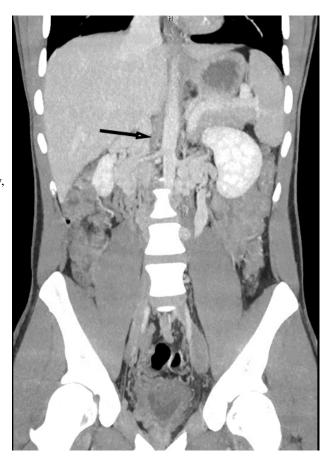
CT venogram coronal view with the black arrow demonstrating the absence of IVC adjacent to the abdominal aorta at the T12 vertebral level.
